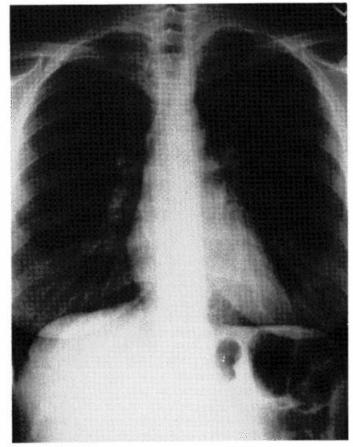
Normal baseline chest X-ray, 1988.
